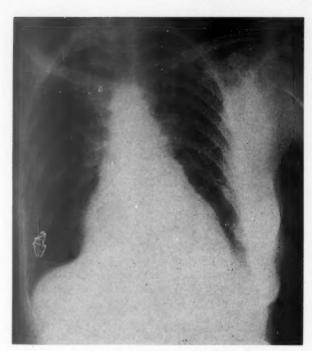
Case 2. Posteroanterior roentgenogram.
